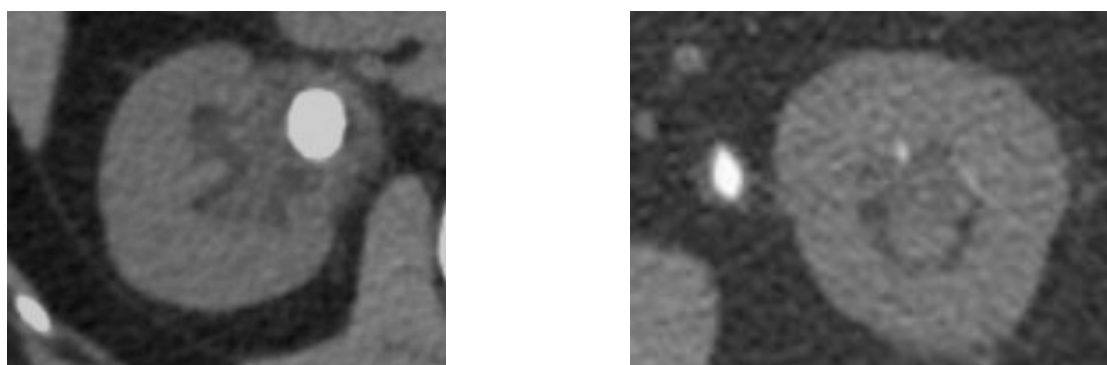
CT scan revealing multiple stones causing bilateral ureterohydronephrosis and acute kidney failure. The stones show low attenuation (low HU values).
